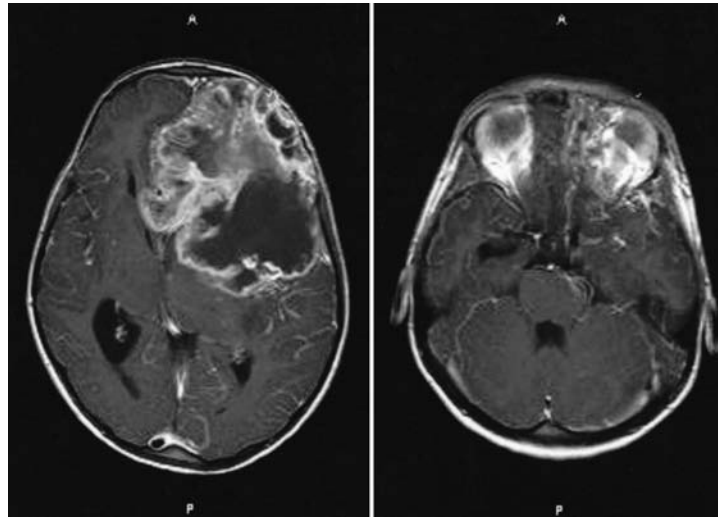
Case 1. Axial T₁-weighted Gd-enhanced MR images obtained in a 9-year-old girl. *Left:* A large, cystic, hypervascularized tumor of the left frontotemporal region with marked mass effect on surrounding structures. *Right:* Hypervascularization of the left orbital and periorbital region can be seen.
